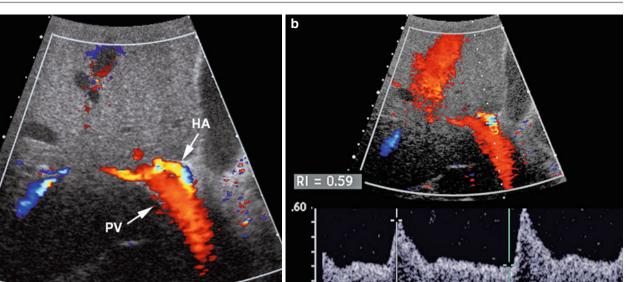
Hepatic artery waveform. (a) Color Doppler image of porta hepatis demonstrating high flow in the hepatic artery (*arrow*, *HA*) adjacent to the portal vein (*arrow*, *PV*), which has slower flow. (b) Spectral
